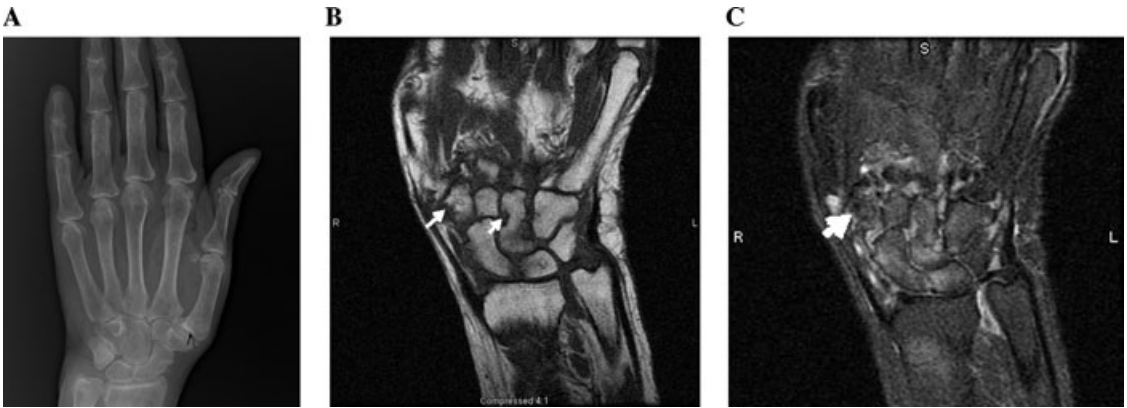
Postero-anterior (PA) (A) views of the left hand of a 76-year-old woman with RA. The bones are diffusely osteopenic. Some erosions show in the PA view at the 1st CMC joint. Coronal T1 (B) and coronal T2-weighted fast spin-echo with fat saturation (C) images of the left wrist of the same woman. The MRIs better demonstrate findings of RA with multiple low-signal erosions (white arrows in B) seen in the wrist on the T1-weighted images. Proliferative synovitis is seen as a bright signal within the joint spaces on the T2-weighted images. Bone marrow edema is also seen on the T2 images as a bright signal within the bone.
